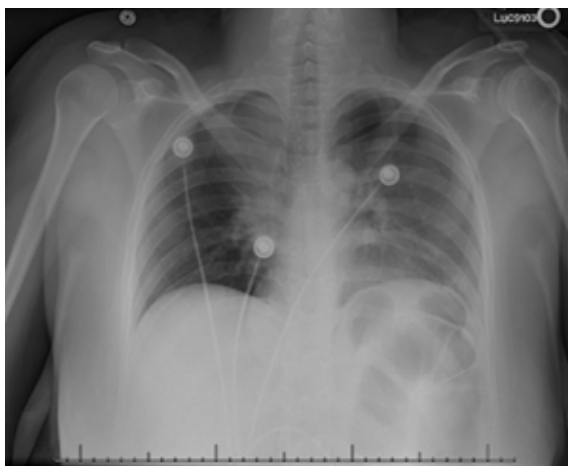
Chest X-ray showing low lung volumes.
